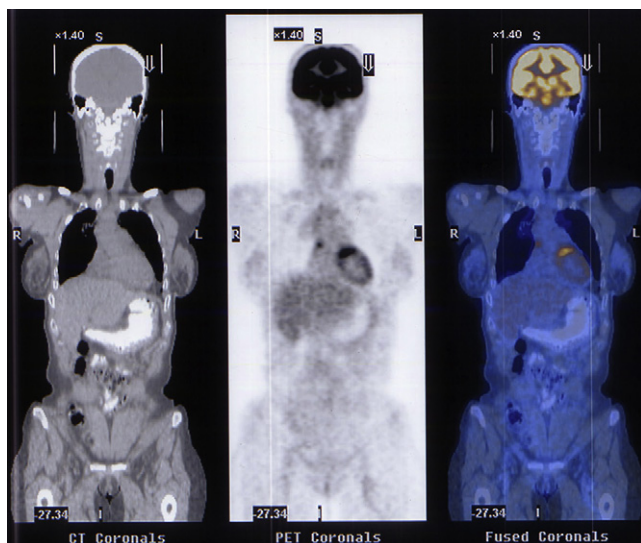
18F-FDG-PET/CT, after 4 months of treatment, with an increased of tracer uptake in the right lung hilum and precaval lymphadenopathies without another significant data in the rest of the examination.
